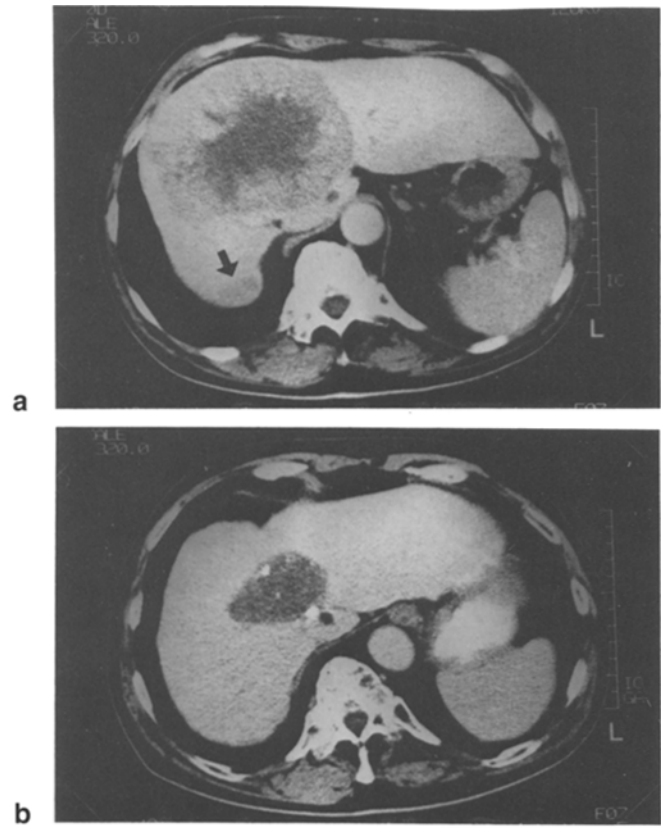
a, b. CT images obtained a prior to and b after EAP-TAE therapy in a 72-year-old man with HCC (a) A large tumor is visible in the liver, and a daughter nodule (↑) is seen in the right hepatic lobe (b) The tumor has decreased greatly in size, and the daughter nodule has disappeared completely
